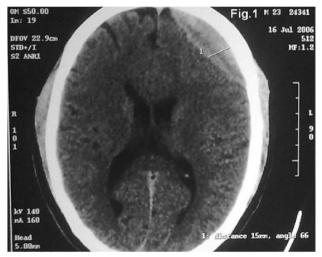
30 year's old male with left frontal EDH. Axial Non contrast CT shows an epidural hematoma over left frontal region with mass effect (CT done on 16th July 2006).
